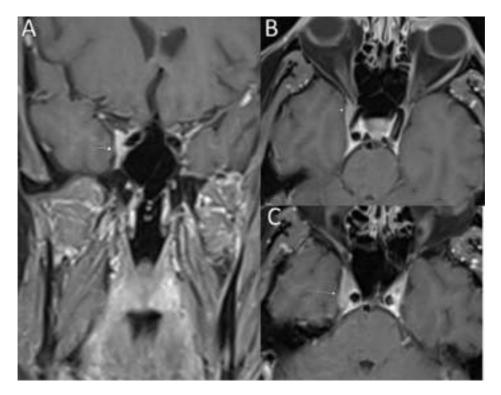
Figure I 57-year-old man with multiple cranial neuropathies. Coronal (A) and axial (B and C) contrast-enhanced TI-weighted MR images showing a nodular enhancing lesion within the anterior right cavernous sinus (arrows) (B-cell lymphoma on biopsy).
